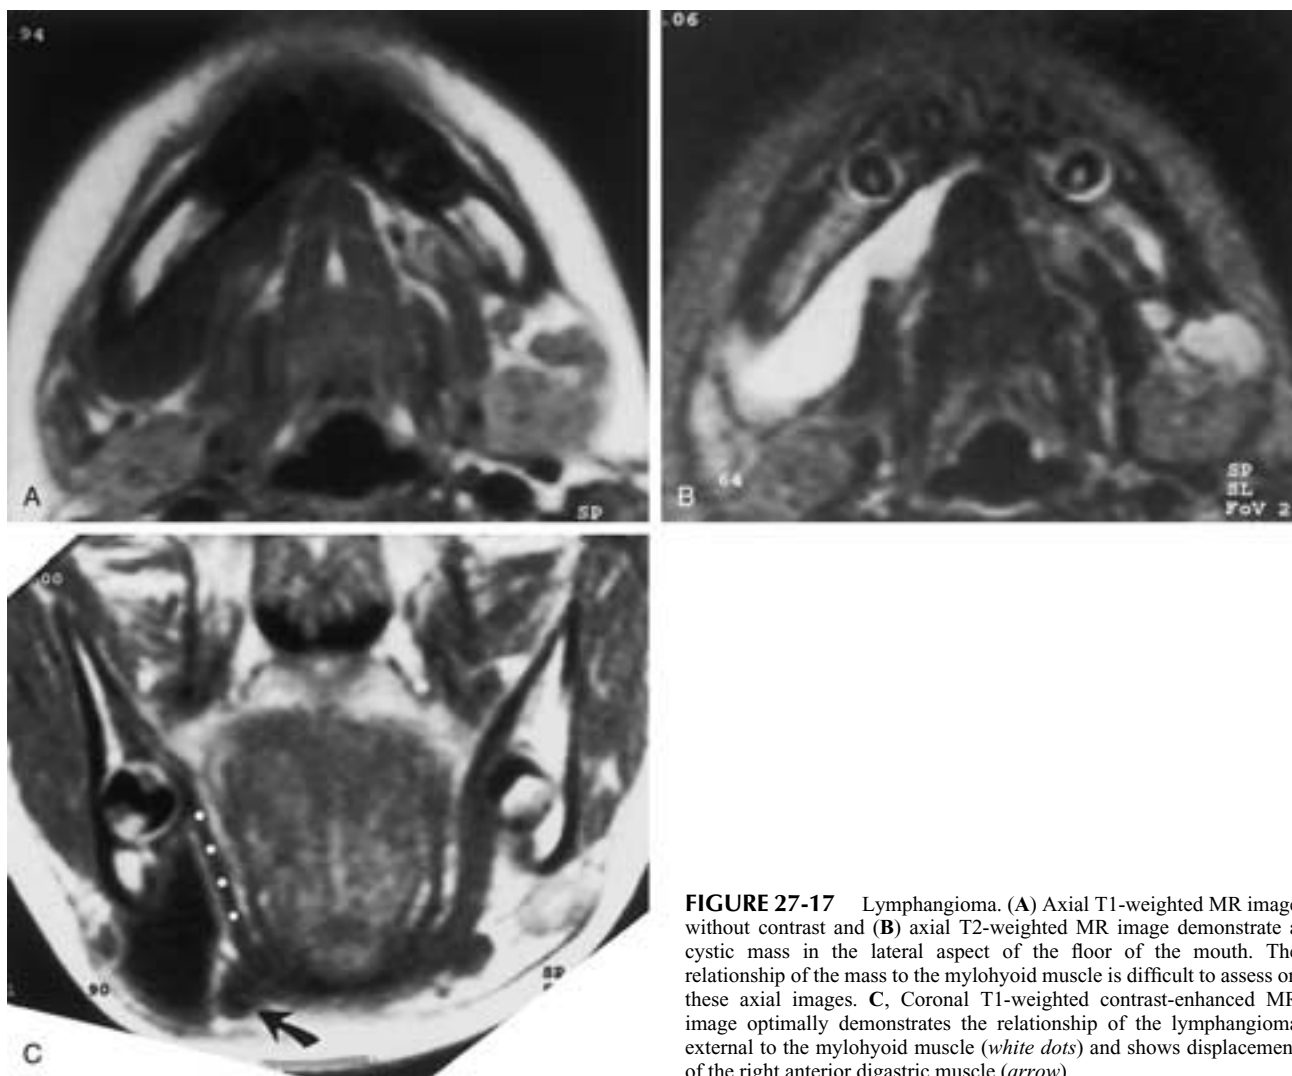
Lymphangioma. (A) Axial T1-weighted MR image without contrast and (B) axial T2-weighted MR image demonstrate a cystic mass in the lateral aspect of the floor of the mouth. The relationship of the mass to the mylohyoid muscle is difficult to assess on these axial images. C, Coronal T1-weighted contrast-enhanced MR image optimally demonstrates the relationship of the lymphangioma external to the mylohyoid muscle (*white dots*) and shows displacement of the right anterior digastric muscle (*arrow*).
